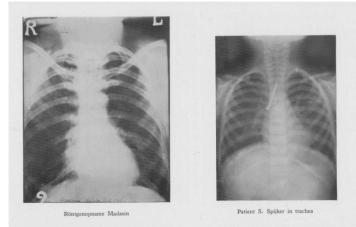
(left) Rontgenopname Madasin; (right) Patient S. Spijker in the trachea Translation: (left) Radiograph of Madasin; (right) Patient S.Paku in the trachea Source: (Gulik, 1930:76) Gulik
